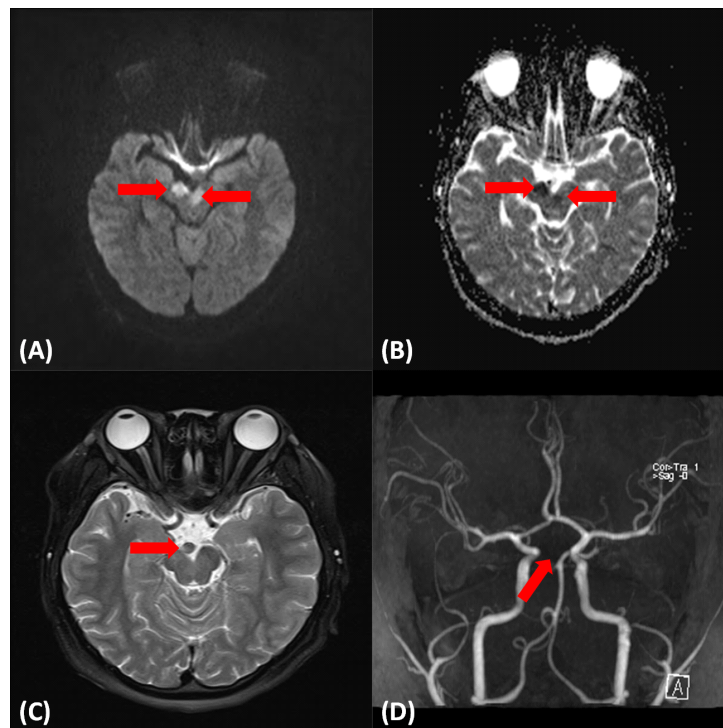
Axial Image of brain MRI of bilateral midbrain infarction (A) T2WI, (B) ADC, hemorrhage in the right interpeduncular cistern (C) T2WI, MRA of circle of Willis with the right P1 segment aplasia (D) T2WI.
